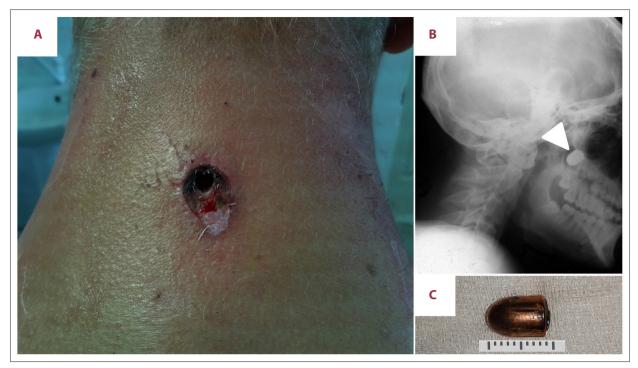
A 16-year-old Ukrainian boy shot at close-range to the back of the neck with a handgun. (A) The entrance wound at the back of the neck is from a Makarov pistol and shows some tissue damage and blood clot. (B) A lateral X-ray of the head and neck shows the bullet trajectory and the location of the bullet lodged in the left pterygopalatine fossa, deep to the infratemporal fossa, and posterior to the maxilla. (C) The 9×18-mm bullet shell was removed, intact, following surgery.
